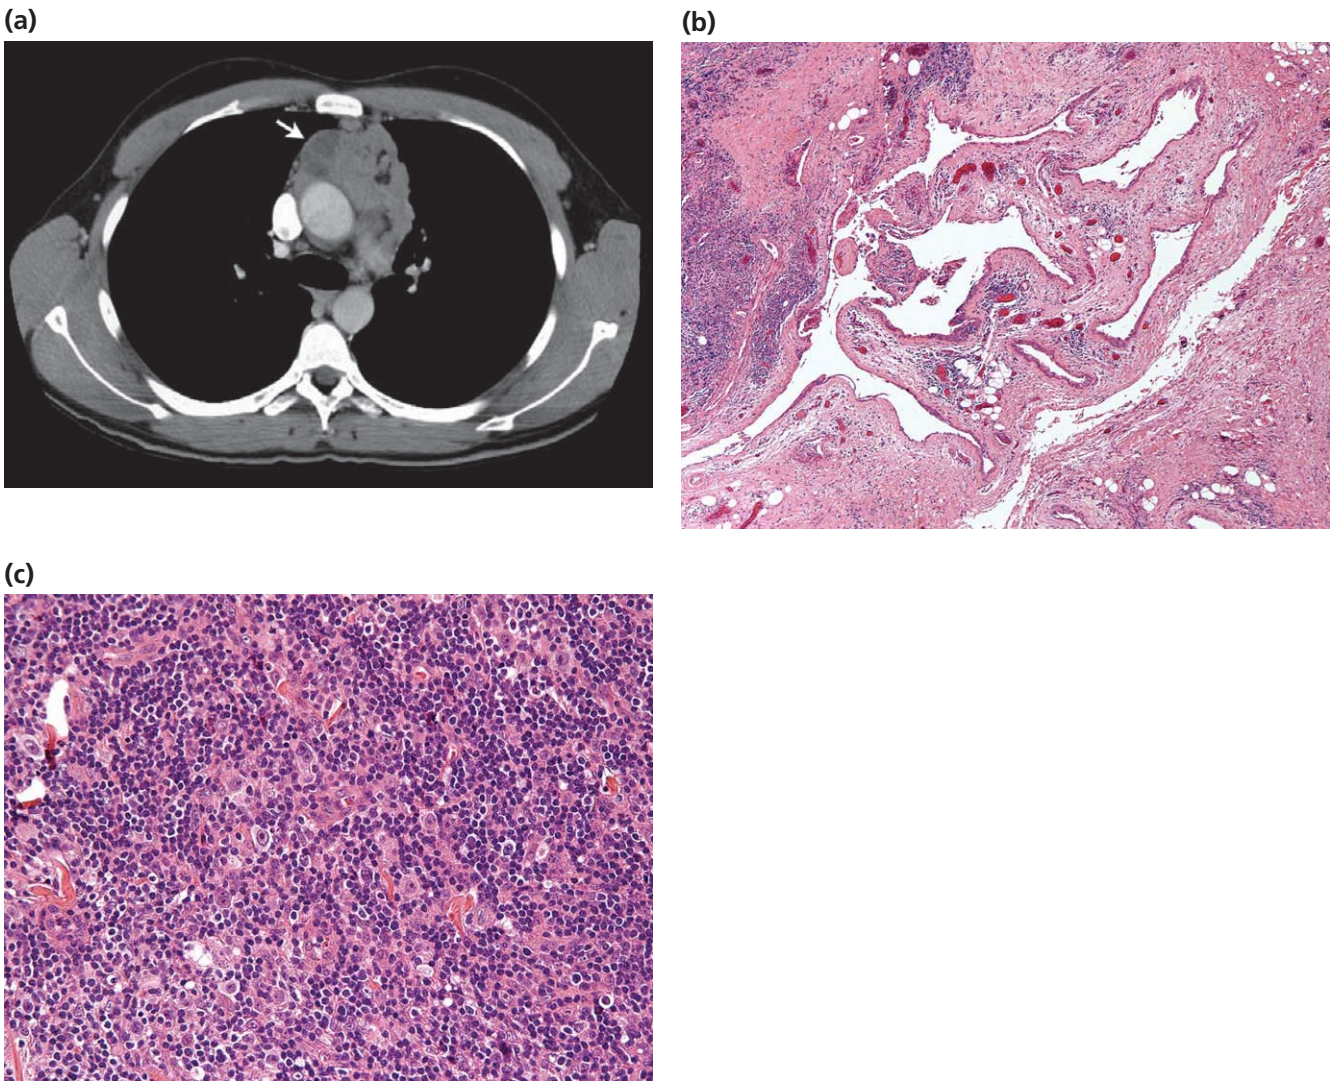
(a) A 33-year-old man with a large anterior mediastinal mass. The surgeon performed an incisional biopsy of the most accessible portion of the lesion, and this happened to be cystic (arrow). (b) The initial FS showed benign thymic cysts. (c) Because the findings on CT scan are those of a malignant neoplasm, a second biopsy was requested and this showed Hodgkin's lymphoma. It is well known that malignancies such as Hodgkin's lymphoma and seminoma evoke the formation of epithelial lined cysts when they involve the thymus gland.
